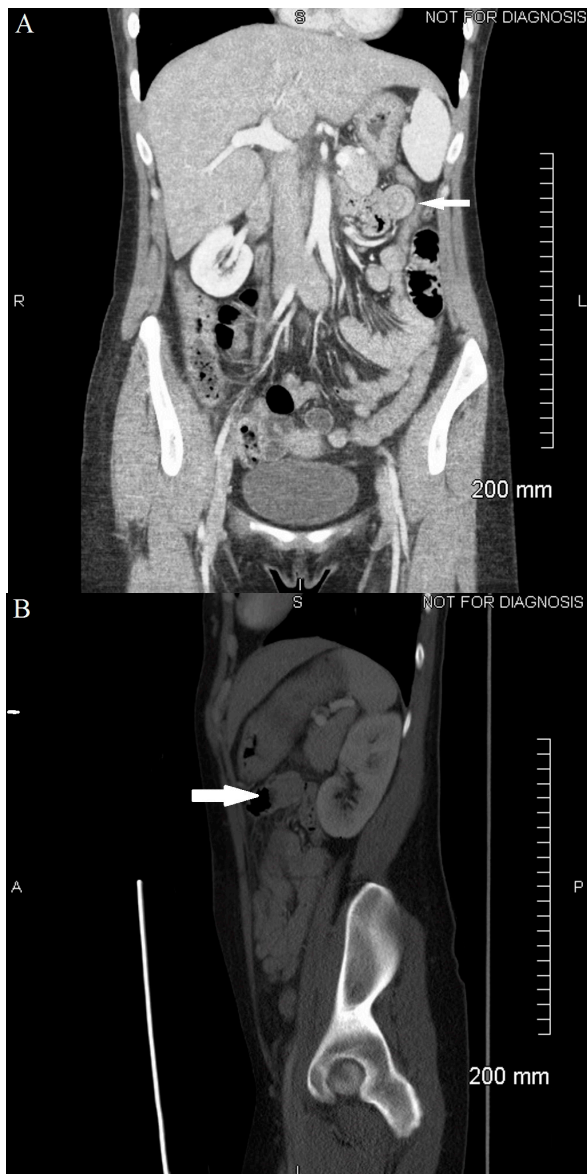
Image AB. Computed tomography (CT) images of the abdomen and pelvis demonstrating transient, non-obstructive jejunal intussusception: (A) Coronal view depicting the classic “target pattern” (small arrow) in the left upper quadrant; (B) Sagittal view showing the jejunal short segment intussusception (big arrow) without any evidence of bowel obstruction.
